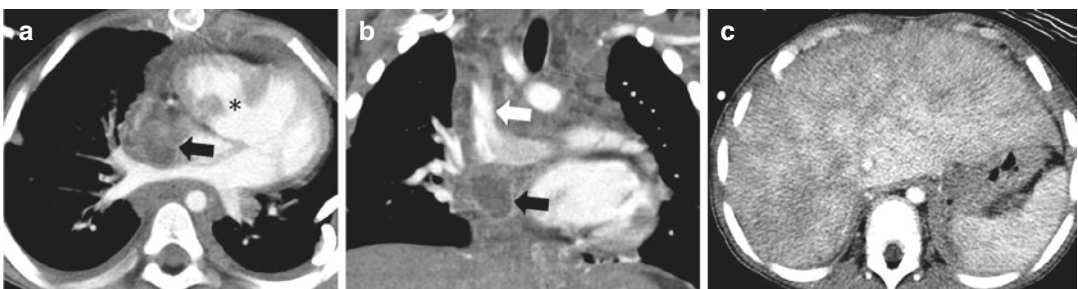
3-year-old male with recent Fontan procedure for double-outlet *right ventricular repair* and acute thrombosis of the Fontan conduit. Axial (a) and coronal (b) CTA images show a heterogeneous peripherally enhancing filling defect within the extracardiac inferior vena cava to
